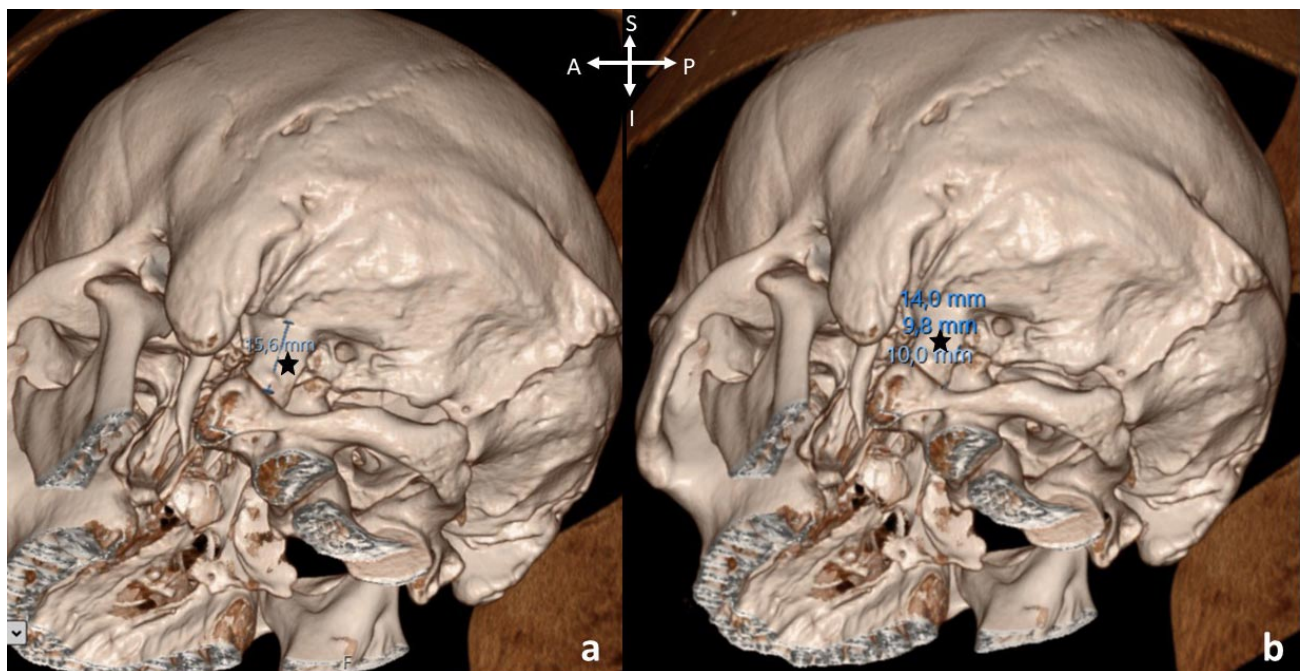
Three-dimensional computed tomography images of the craniovertebral region and paracondylar process. (a) Shows total length of the paracondylar process (black star) (15.6 mm). (b) Shows paracondylar process's (black star) base, midpoint, and apex lengths (14, 9.8, and 10 mm, respectively). A: Anterior, P: Posterior, S: Superior, I: Inferior.
